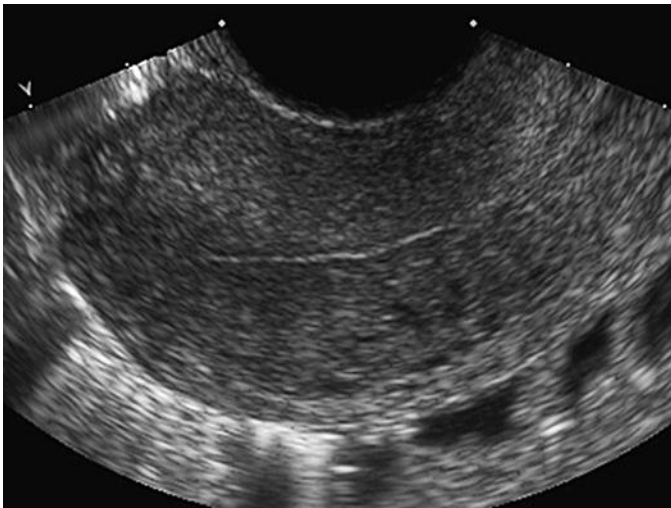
Normal ultrasound appearance of the endometrium during the menstrual phase. Gray-scale transvaginal sagittal image of the uterus demonstrates a thin, linear echogenic endometrium.
